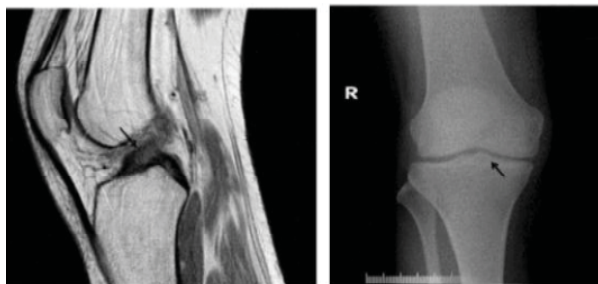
(a) MRI of a 24 year old male patient showing ACL strain revealing the abnormal contour of the ACL (arrow) and the corresponding AP view of plain radiograph is shown in Fig. 1(b) AP view of plain radiograph of a 24 year old male patient showing prominence of medial intercondylar eminence (arrow).
